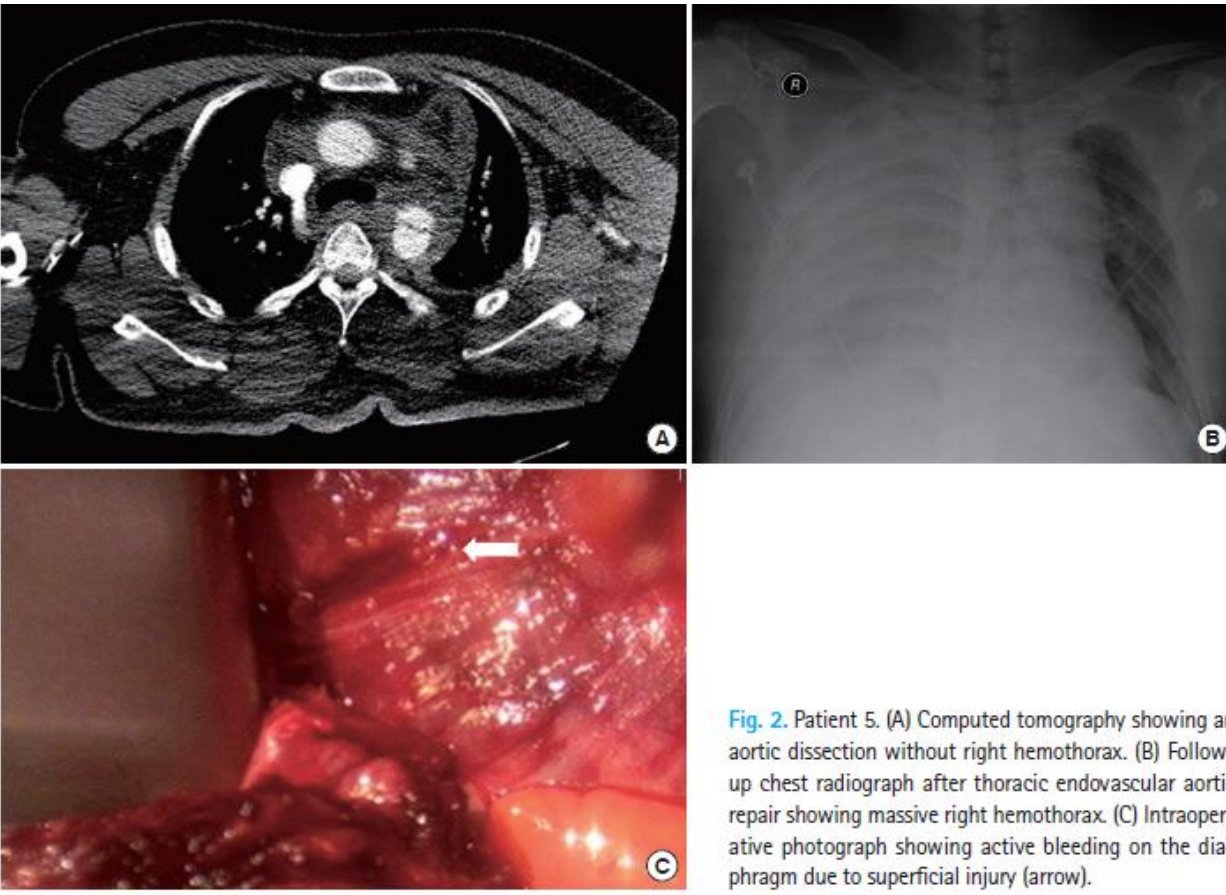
Patient 5. (A) Computed tomography showing an aortic dissection without right hemothorax. (B) Follow-up chest radiograph after thoracic endovascular aortic repair showing massive right hemothorax. (C) Intraoperative photograph showing active bleeding on the diaphragm due to superficial injury (arrow).
